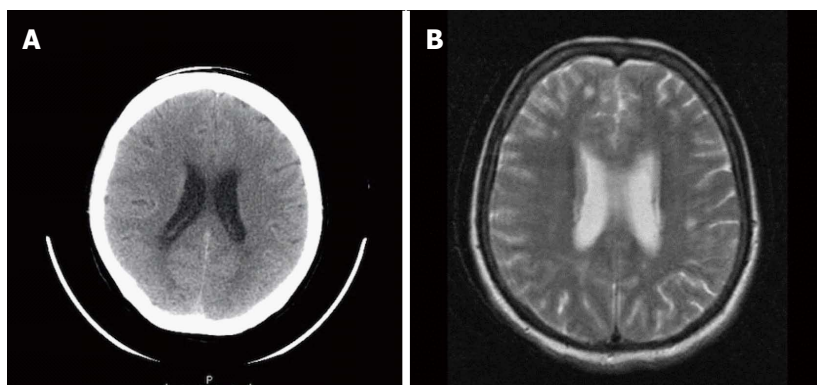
Patient No. 1. A: Computed tomography brain did not reveal brain lesions; B: Magnetic resonance imaging brain showed findings consistent with leptomeningeal carcinomatosis.
